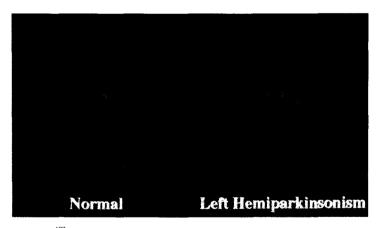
[123]β-CIT SPECT images of a healthy subject and of a patient with hemiparkinsonism. In the patient with hemiparkinsonism, [123]β-CIT binding is reduced not only in the striatum contralateral to the clinical symptoms but also in the ipsilateral striatum. Note that left is on the right in the figure.
